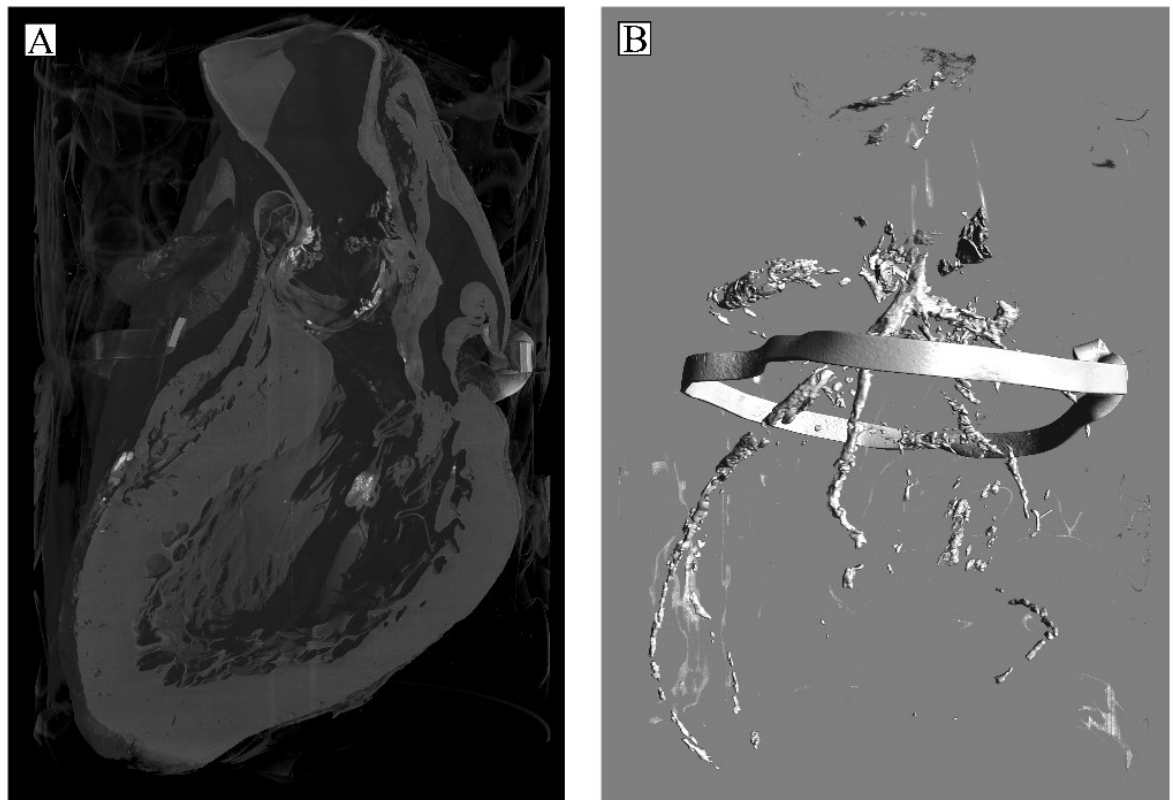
μ CT scan of a human heart with a section cut away (A), the same scan displaying the calcified plaques present in the heart, as well as an elastic band (B).
